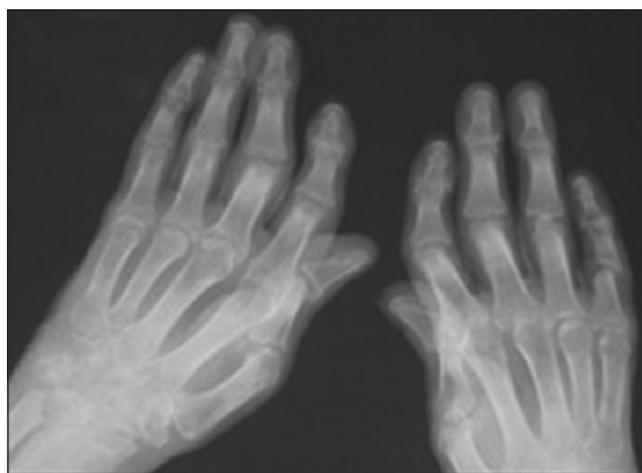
X-ray of hands showing advanced degeneration of the left wrist with the collapse of the carpal bones.
